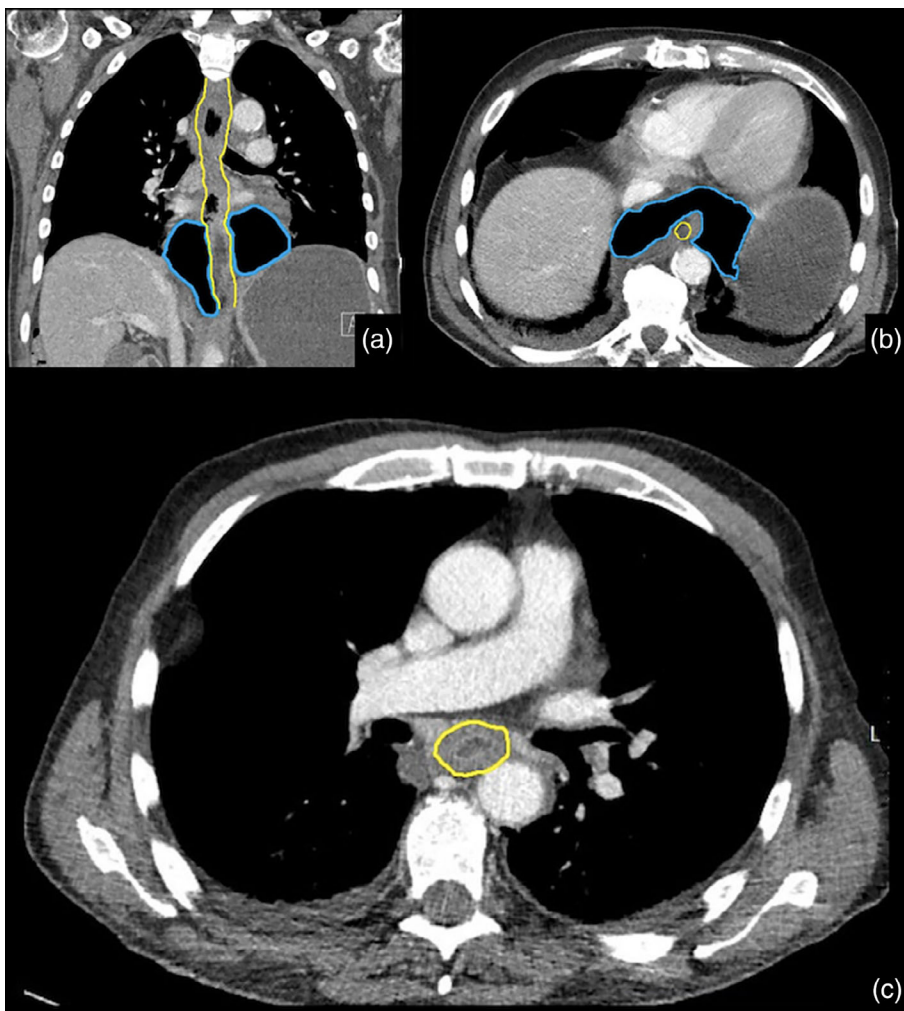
Computed tomography imaging with coronal (a) and axial view (b,c) revealing massive pneumomediastinum surrounding the distal oesophagus. Blue marking: Pneumomediastinum. Yellow marking: Oesophagus.
